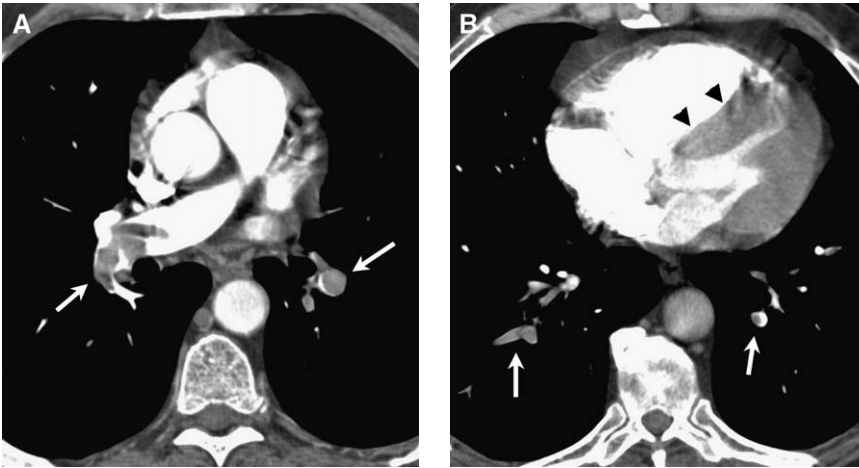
Pulmonary emboli. (A) Filling defects are present bilaterally (arrows), in the right pulmonary artery, extending into the right descending pulmonary artery, and in the left descending pulmonary artery. (B) Thromboemboli are visible as filling defects (arrows) in the segmental and subsegmental pulmonary arteries of both lower lobes. The clot burden caused an increase in right heart pressures, with right ventricular dilatation and bowing of the interventricular septum (arrowheads) visible on CT.
